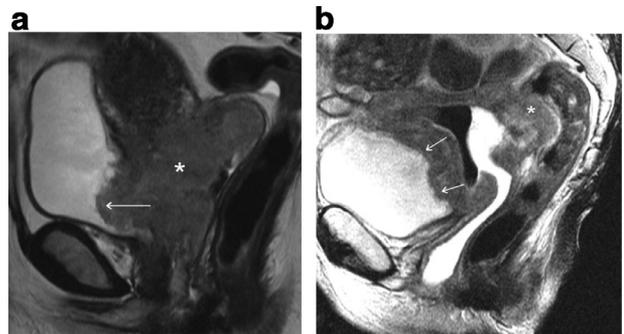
Stage IV Invasion of adjacent organs. (a) Sagittal T2 weighted MRI of the pelvis reveals a large cervical tumor (asterisk) with bladder invasion. (b) Sagittal T2 weighted MRI of the pelvis with vaginal gel demonstrates a large tumor with invasion of the posterior bladder wall (arrows) and rectal involvement (asterisk).
